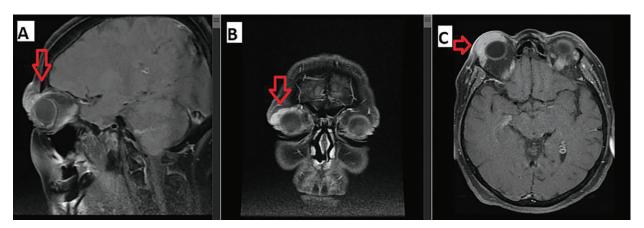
Sagittal (A), coronal (B) and axial (C) MRI images of the tumour lesion in the right orbit
